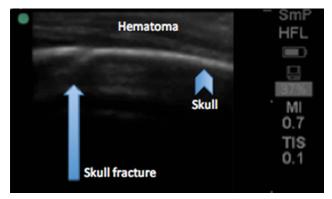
Point-of-care ultrasound image utilizing a high-frequency linear transducer demonstrates the patient's right nondisplaced parietal skull fracture.
